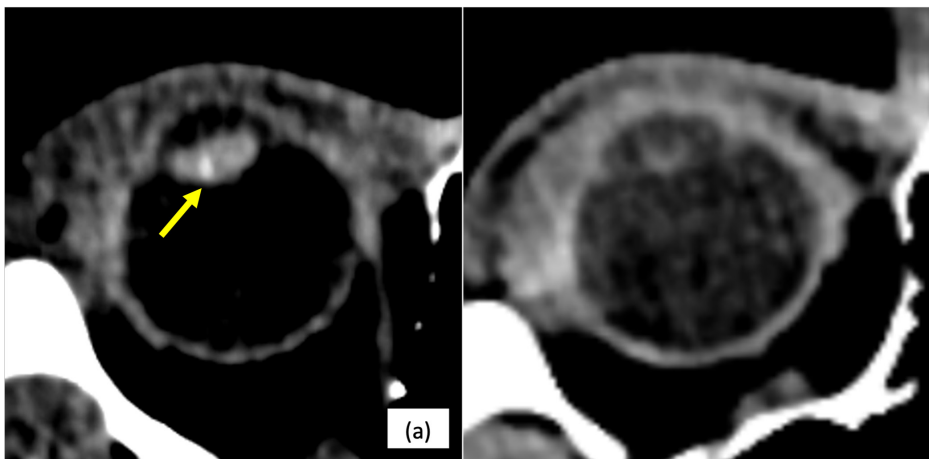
(a) Preoperative CT of the orbit showing a small hyperdense focus in keeping with an intralenticular foreign body. (b) Postoperative CT showing pseudophakia with no residual foreign body.
